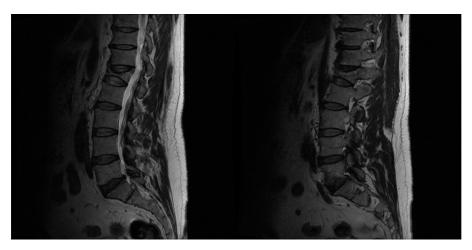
Compression fractures of the L1 vertebrae visible in lumbar spine MRI
